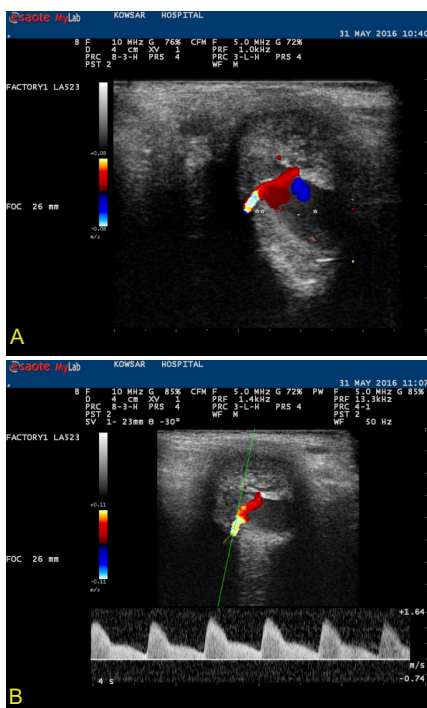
(A) color-flow sonogram shows an area of color flow aliasing within the left corpus cavernosum near the base of penis. This is consistent with the presence of an arterio-lacunar fistula. (B) Corresponding color flow, Doppler reveals continuous diastolic flow confirming the arterio-lacunar fistula.
